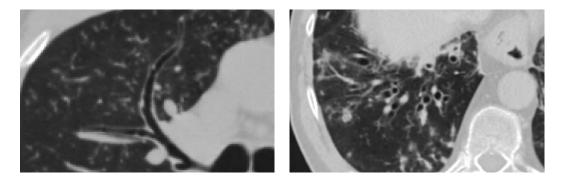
Examples of chest CT scans with bronchiectasis. LEFT: A bronchiectatic airway showing a lack of taper. RIGHT: Bronchiectatic airway being larger than its accompany pulmonary artery.
